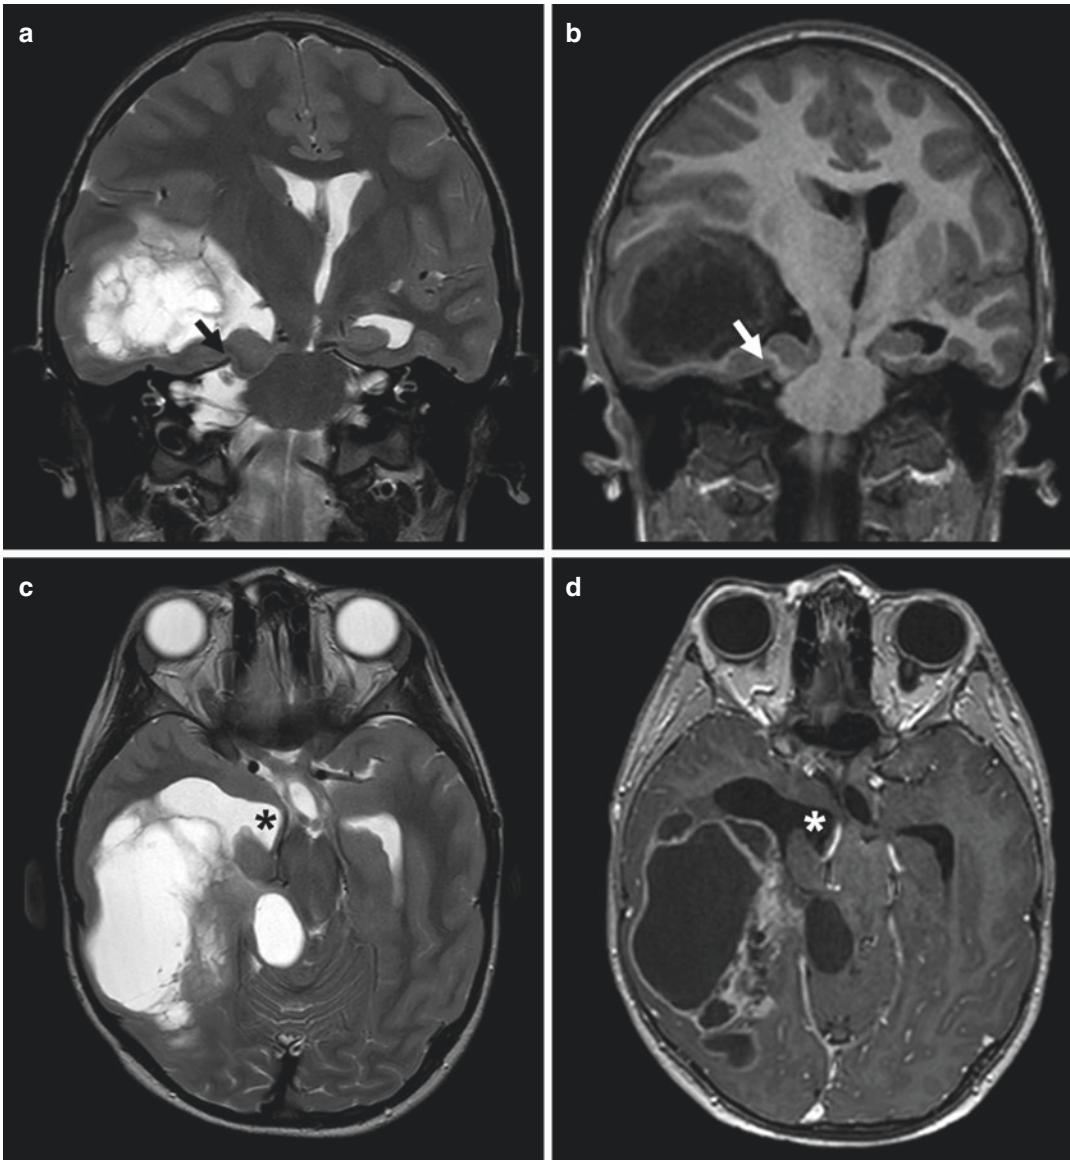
Descending transtentorial herniation. Neoplastic intracerebral mass of right temporal lobe causing mass effect and descending transtentorial herniation of medial temporal lobe through the tentorial incisura (arrow), as shown in coronal T2-weighted (a) and T1-weighted MR
